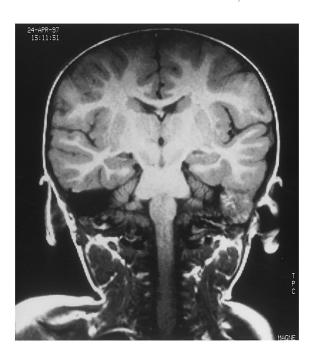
Coronal T1 weighted MRI scan. Abnormal soft tissue in the left mastoid region.
